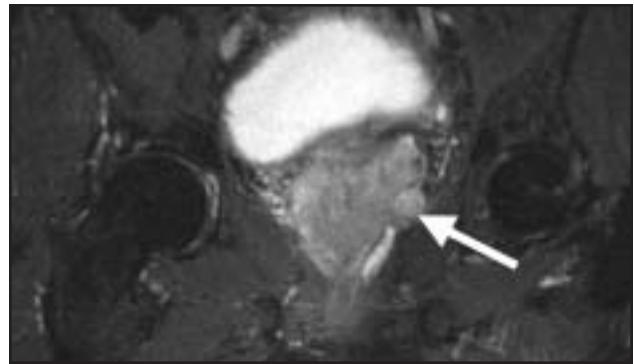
Coronal T2-weighted STIR (short tau inversion recovery) imaging demonstrates extracapsular extension (arrow).
